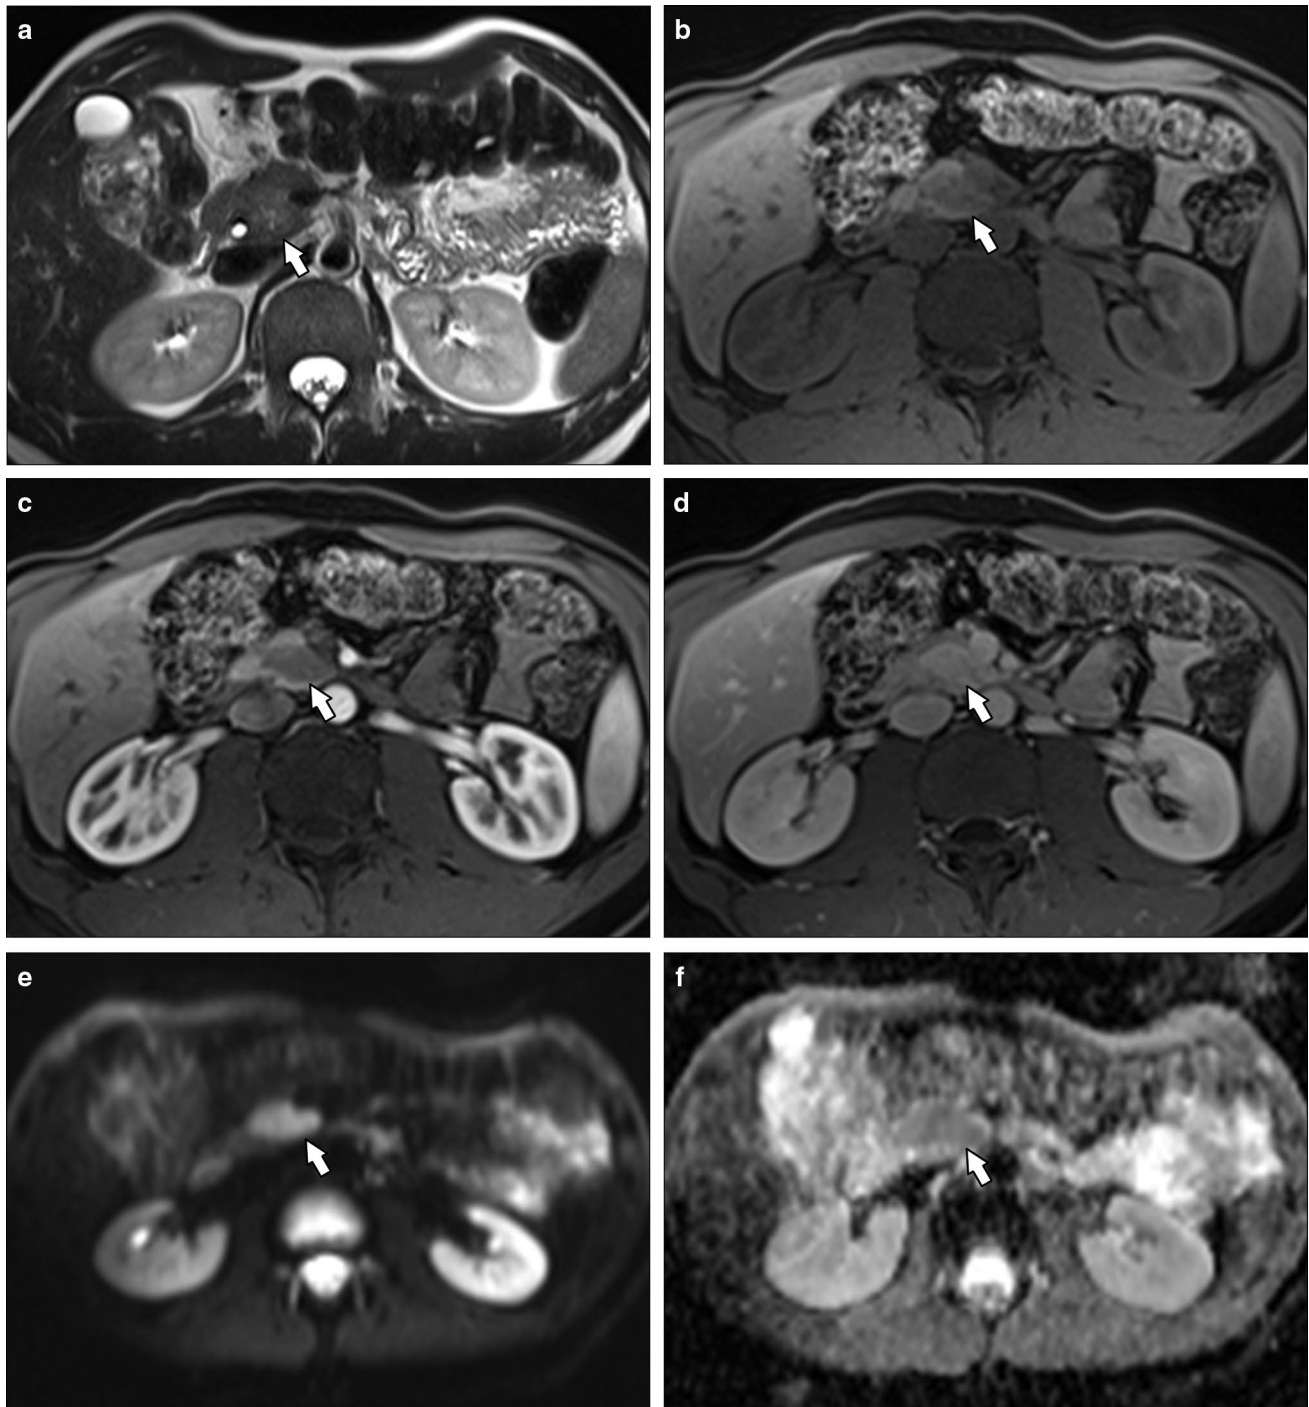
A 29-year-old male with history of recurrent pancreatitis, elevated lipase, and normal serum IgG4. a Axial T2-weighted MR image shows a mildly hyperintense lesion in the uncinus process of the pancreas (arrow). b Axial unenhanced T1 FS MR image shows the lesion to be hypointense (arrow). c Axial T1 FS contrast-enhanced MR arterial phase image shows hypoenhancing lesion
